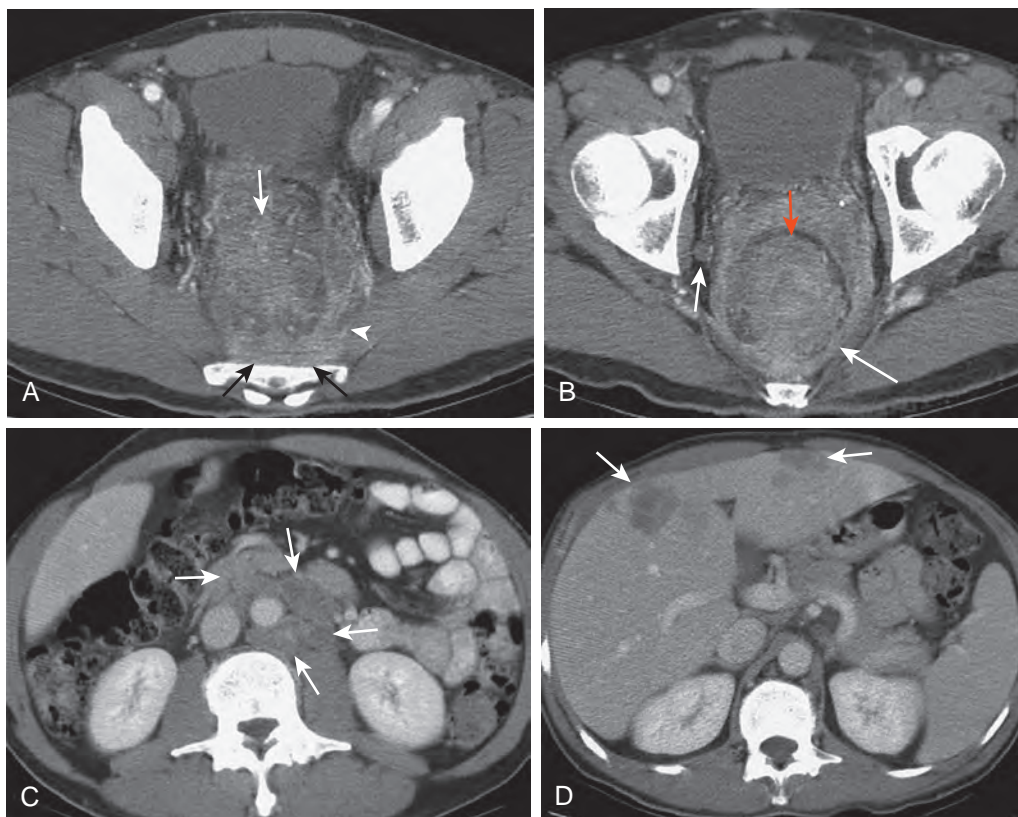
CT scan of primary invasive rectal adenocarcinoma (T4bN2M1; Dukes' stage D). A. Large enhancing rectal mass (white arrow) with extension to pelvic sidewalls. Enhanced mass is inseparable from the sacrum (black arrows) and piriformis muscle (arrowhead) on left. B. Rectal mass (red arrow) directly extends into mesorectal fascia (long arrow). Abnormal internal iliac lymph node (small arrow) also is identified. C. At a level just below the midpole of kidneys, extensive retroperitoneal adenopathy (arrows) is demonstrated. D. Several hepatic metastases (arrows) are seen.
